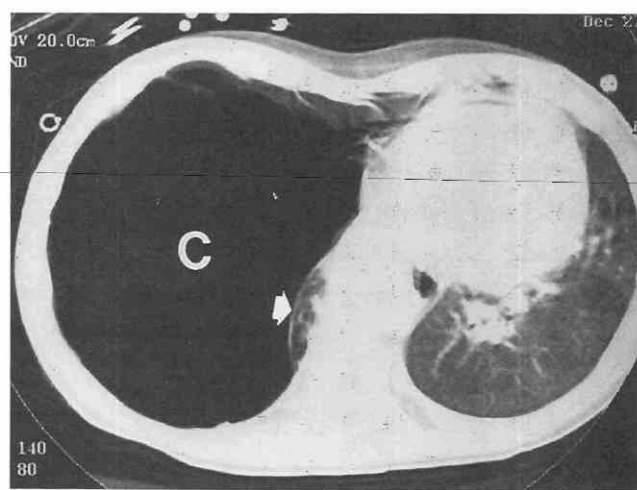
Type 1 congenital cystic adenomatoid malformation in a 16-month-old boy. CT scan shows large air-filled cyst (C) occupying most the right hemithorax. The right lower lobe is compressed (arrow), and there is leftward mediastinal shift.
